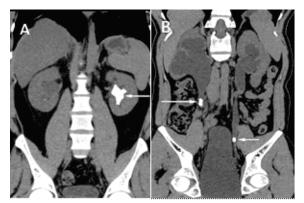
Coronal view of non-contrast CT KUB shows a Staghorn calculus at the left renal pelvis. The density of the calculus is about 1296 HU.
